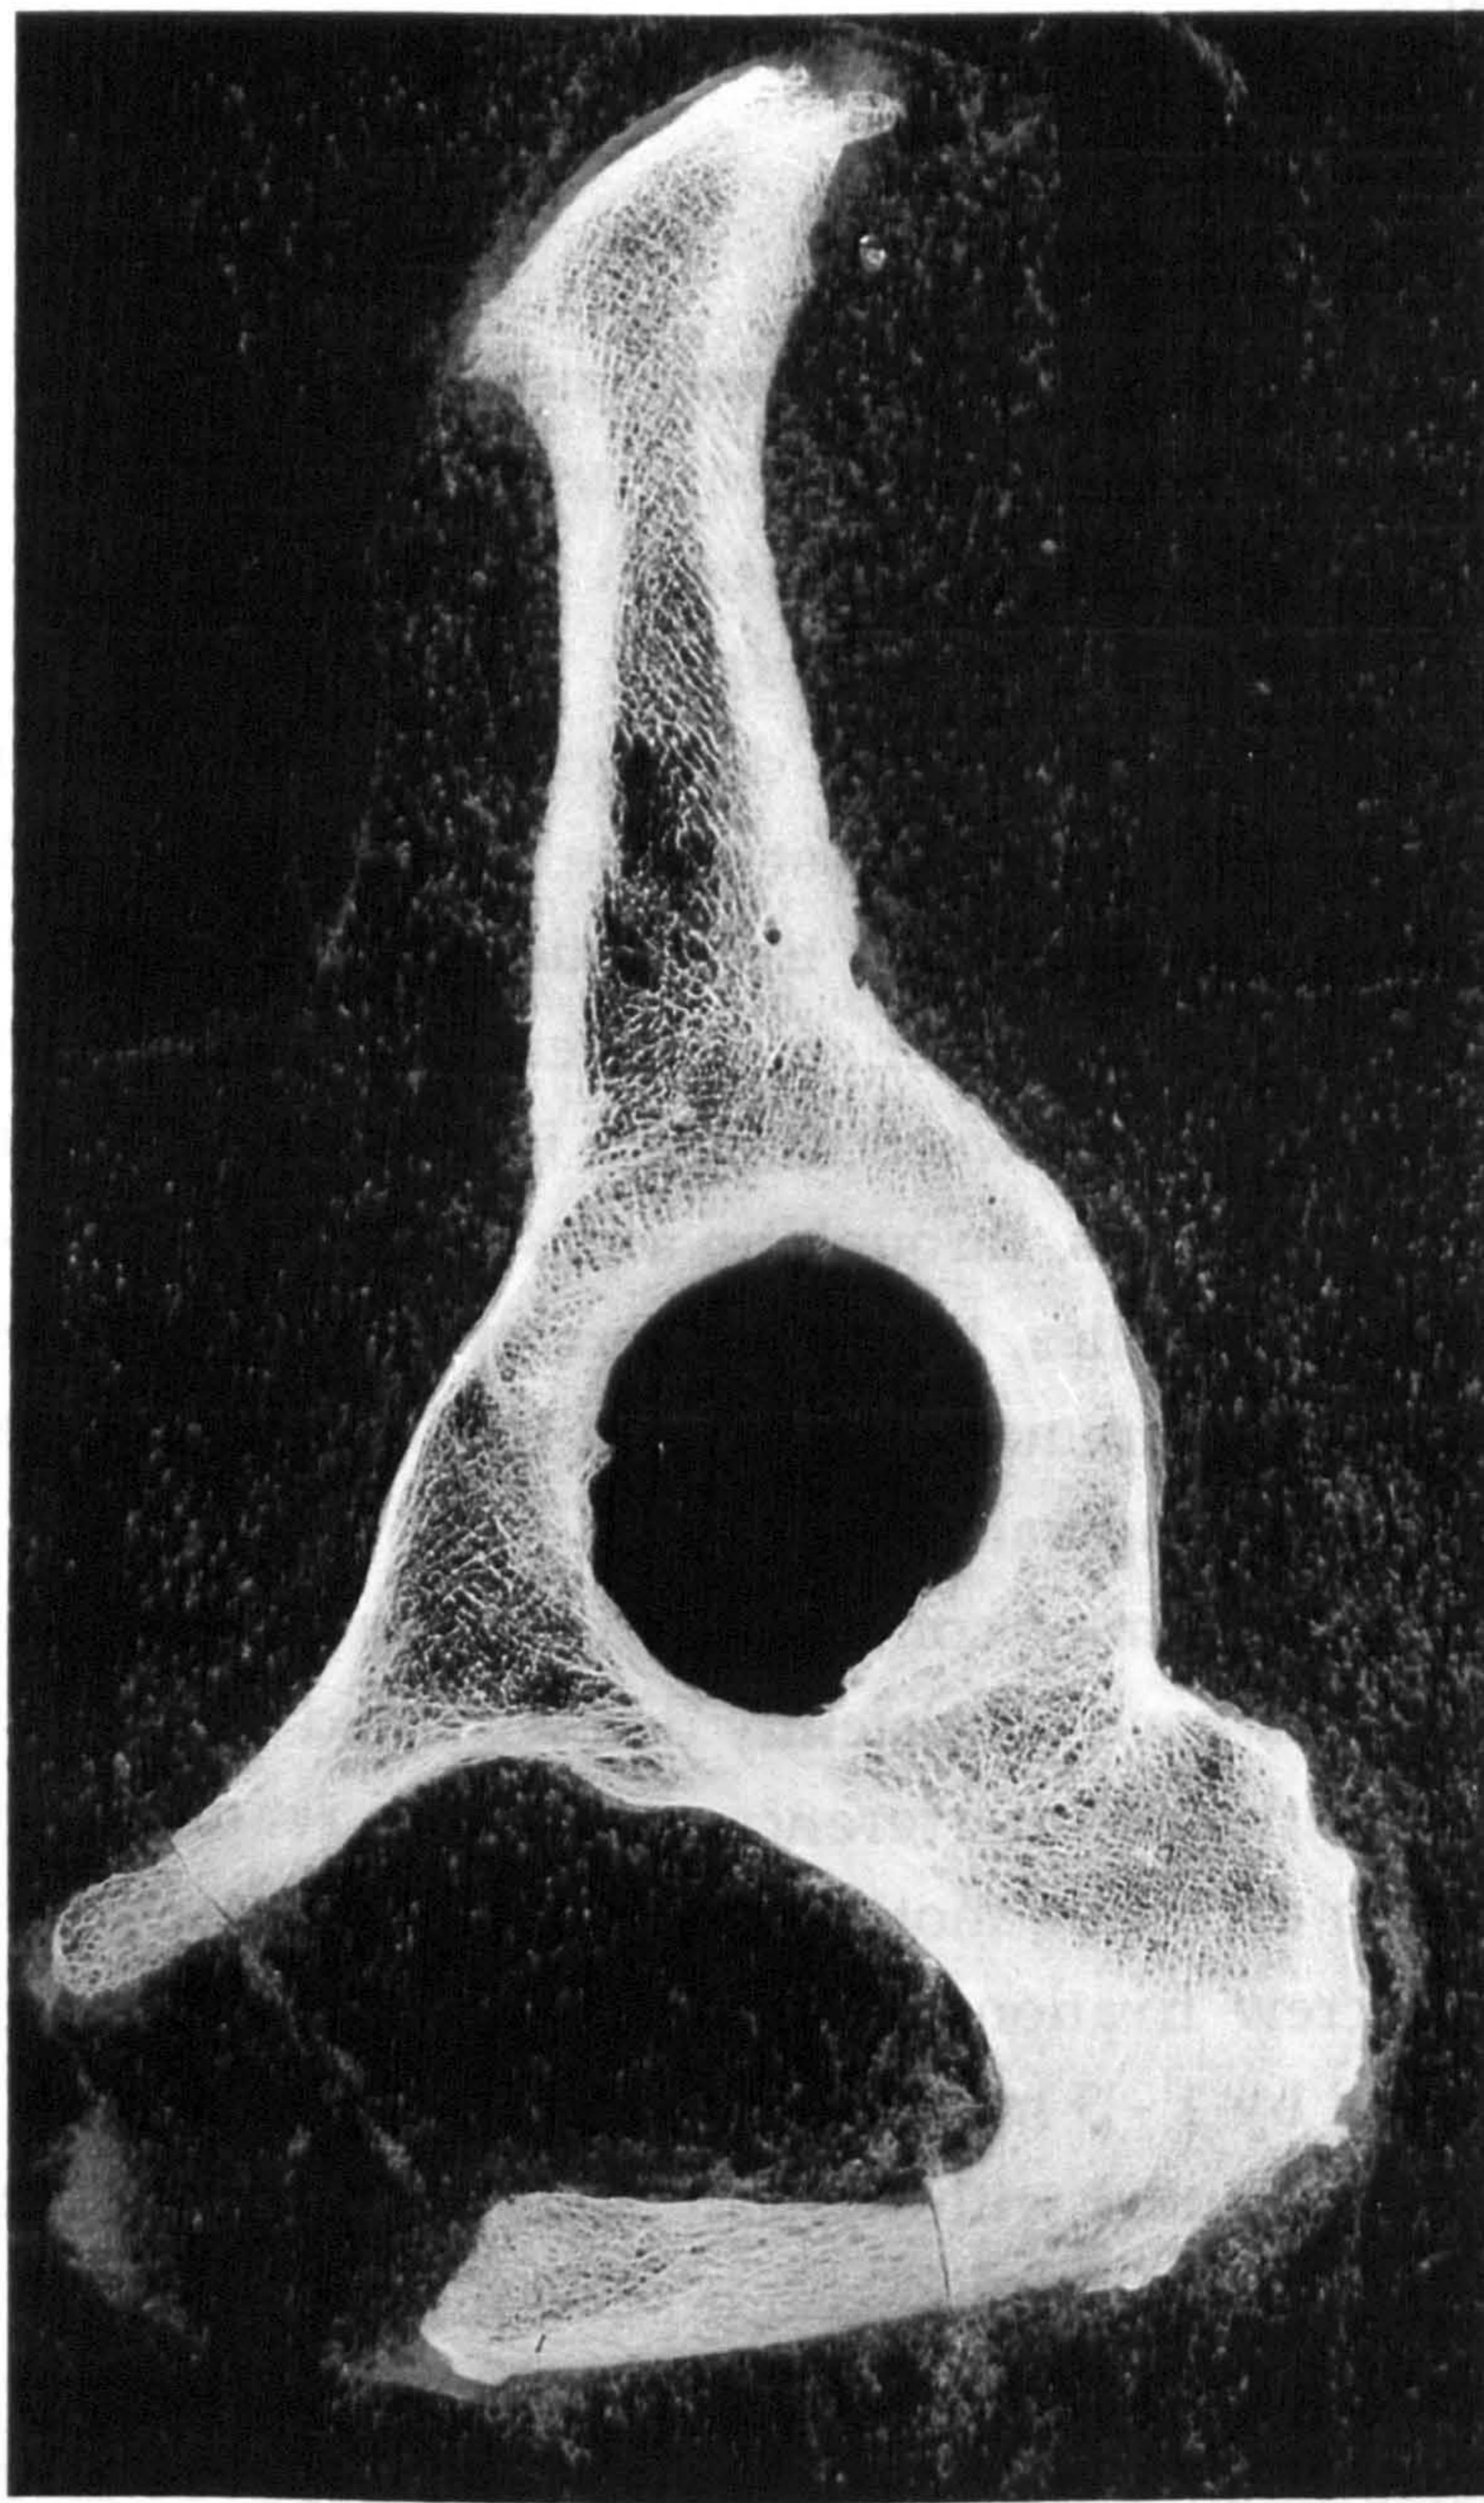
Contact radiograph of a 5 mm slice taken through the pelvis, parallel to, and approximately 10 mm medial to the mouth of the acetabulum.
